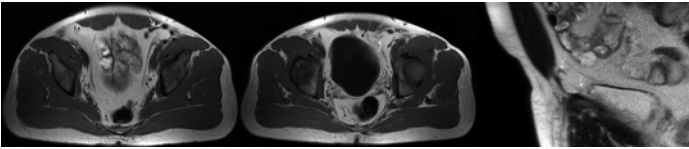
Pair of axial MR T1-weighted images show an example of abnormal laparoscopic mesh (*black arrow*), with areas of irregular central contour (*white arrow*) and numerous tacks. The margins of the mesh are curled and folded (*curved white arrows*). The bladder is distorted (*curved black arrow*), suggestive of local mass effect. Significant adhesions were present at surgical exploration.
